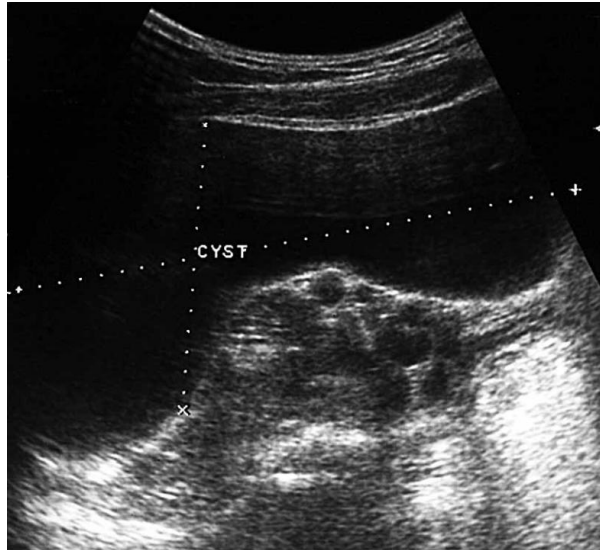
Ultrasonography demonstrating the length and depth of the parovarian cyst
